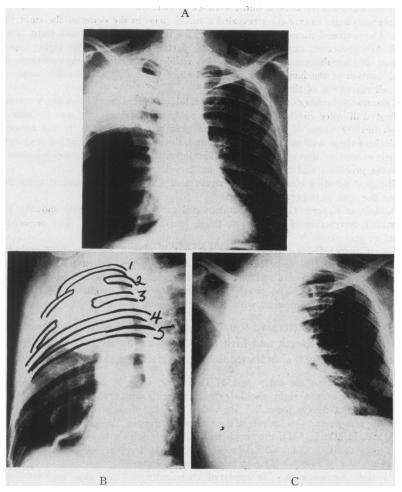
(A and B) Case 2: Routine and overexposed roentgenograms showing a large peripheral squamous cell carcinoma of the lung, with destruction of the 2d and 3d ribs. Note in (A) the clear zone between the mesial border of the tumor and mediastinum.
